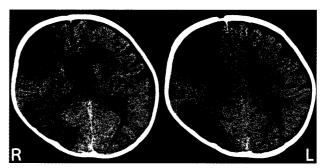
Brain CT (day 1) showed multiple low density areas in the frontal, parietal, and occipital regions mainly in the left cerebral hemisphere.
